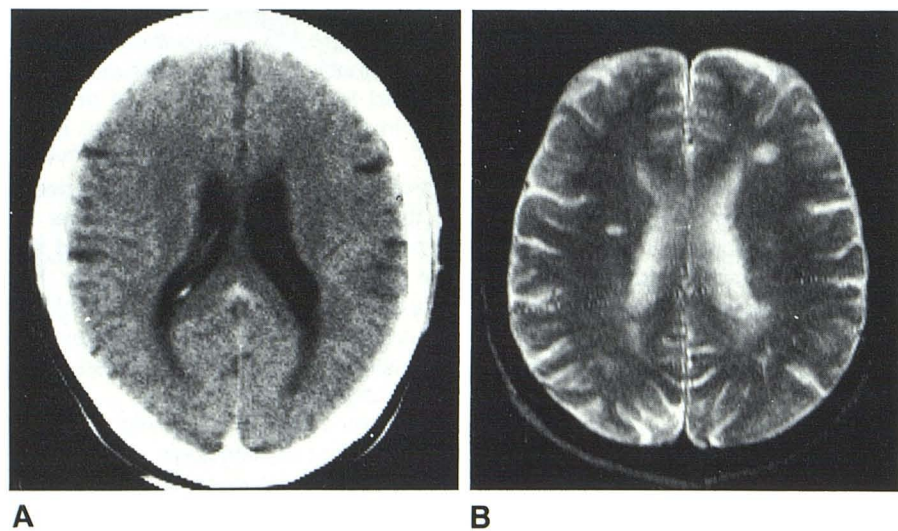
52-year-old man with 5 year history of signs and symptoms of MS. A, Normal CT scan at level of lateral ventricles. B, SE scan, 120 msec TE, 2 sec TR, four buffers, 0.6 T. Two areas of increased signal in periventricular region on this T2-weighted image. T1-weighted images were normal.
